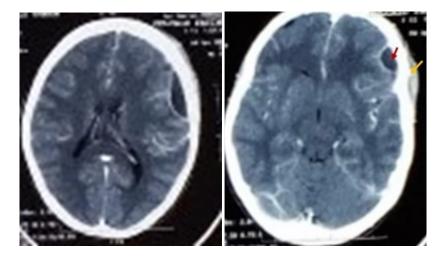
Contrast-enhanced head CT scan with evidence of left frontal subdural empyema and soft tissue swelling with abscess of frontal scalp.
